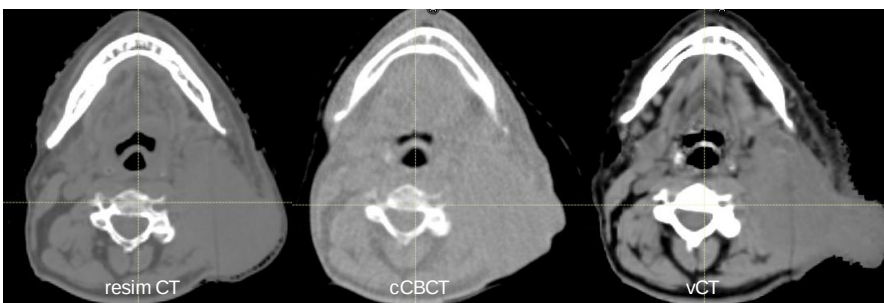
Axial CT images of the same slice for a typical H&N patient.
